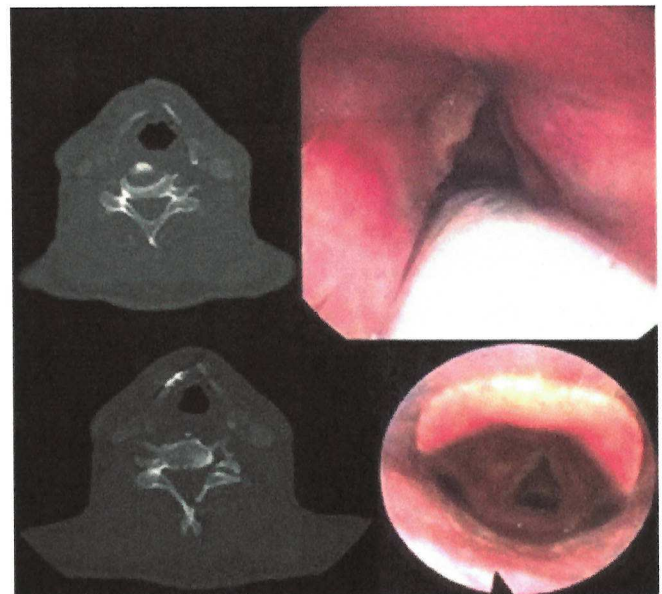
(Up) Preoperative CT scan and fibre endoscopic examination (case 2) show a displaced fracture of the thyroid cartilage on the right side with extensive emphysema and normal laryngeal mucosa. (Down) Postoperative CT scan and 1-month postoperative fibre endoscopic examination (case 2) show symmetric alignment of the thyroid cartilage and no affection of the laryngeal mucosa with normal vocal fold mobility and no endolaryngeal exposure of the miniplates or screws.
